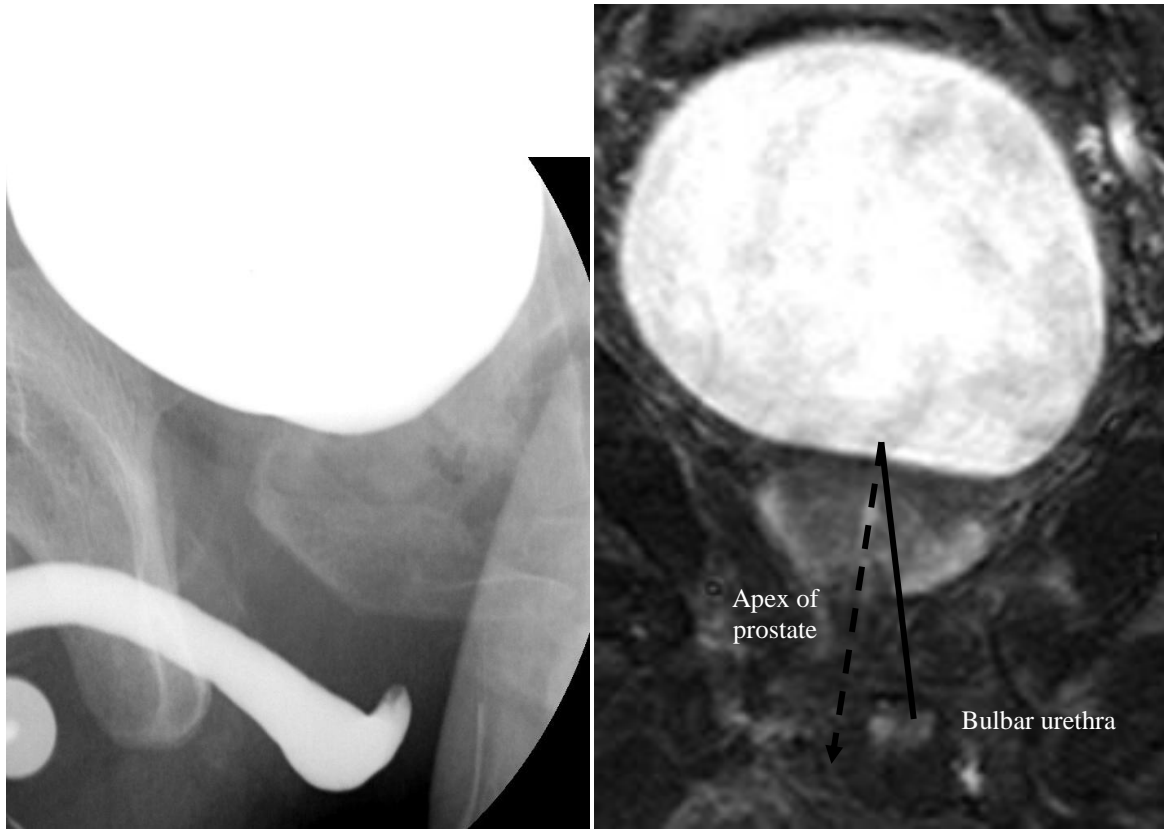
and 17 Prostatic displacement on MCU and MRI in the same patient
